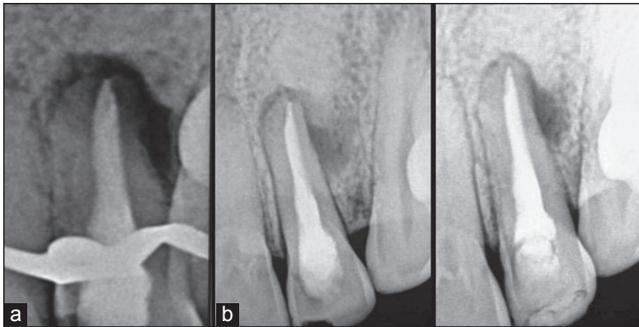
(a) Obturation (b) Postoperative (3-month and 6-month follow-up radiographs)
